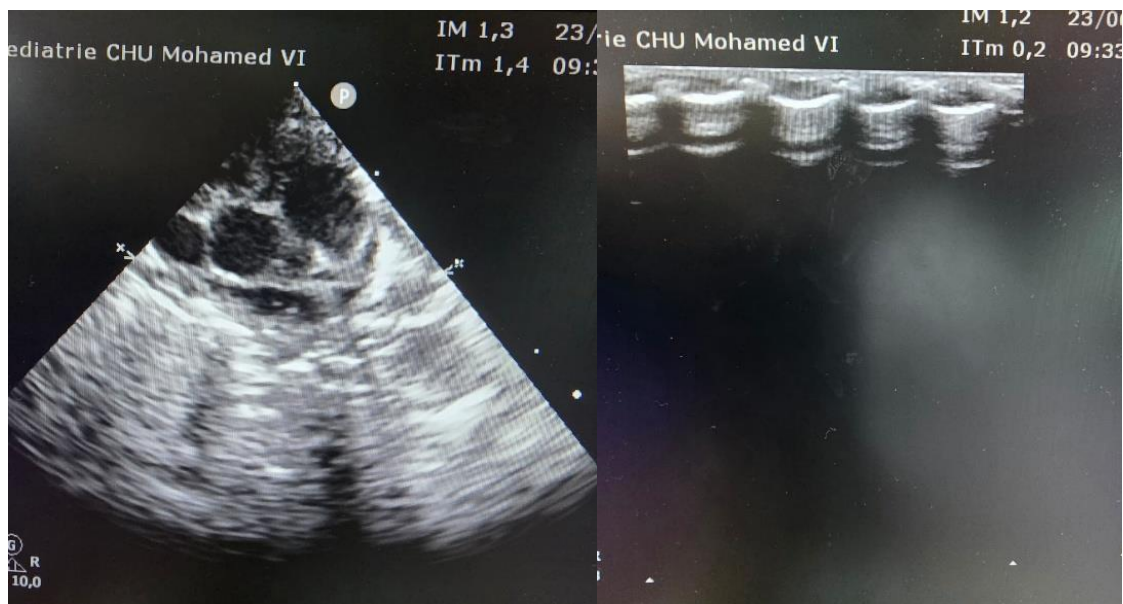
Transthoracic echocardiographic images obtained on day 1 of life, showing situs solitus with a right-sided intrathoracic liver. [Authors: please confirm/complete the specific echocardiographic views and any additional findings shown in each panel.]
